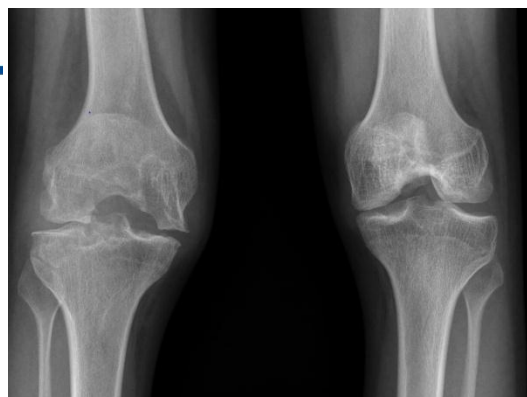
A. Pettersson score, B. X-ray of a 20 year old severe Hemophilia A
